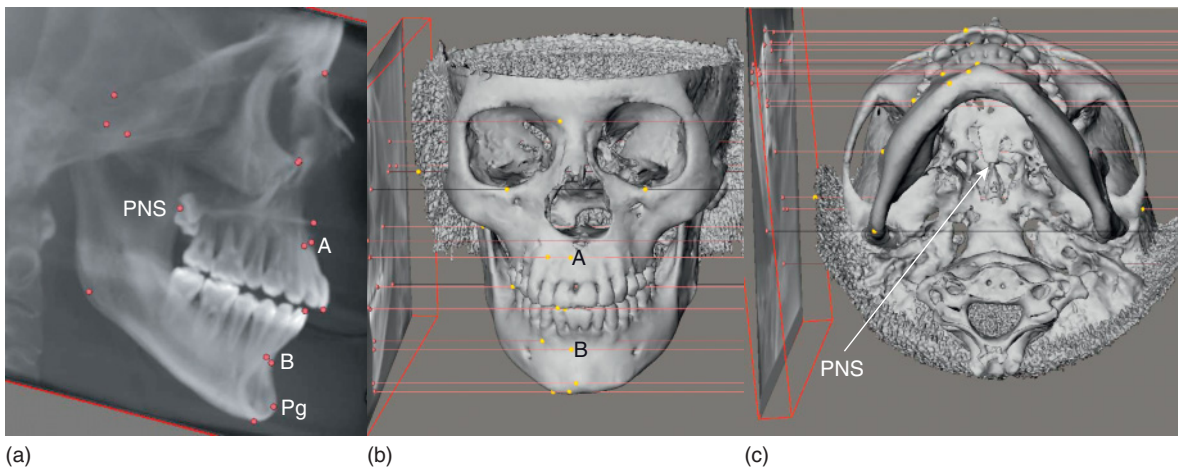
The points are placed on the lateral cephalogram (far left), and these points are projected onto the three-dimensional model. The points on the three-dimensional model do not coincide with the midline points A and B and pogonion (Pg). The postnasal spine (PNS) marked on the radiograph is 8 mm in front of the real PNS. In this example, a cone beam computed tomography scan has been used to generate the three-dimensional model (Maxilim®, Medicim NV, Belgium).
